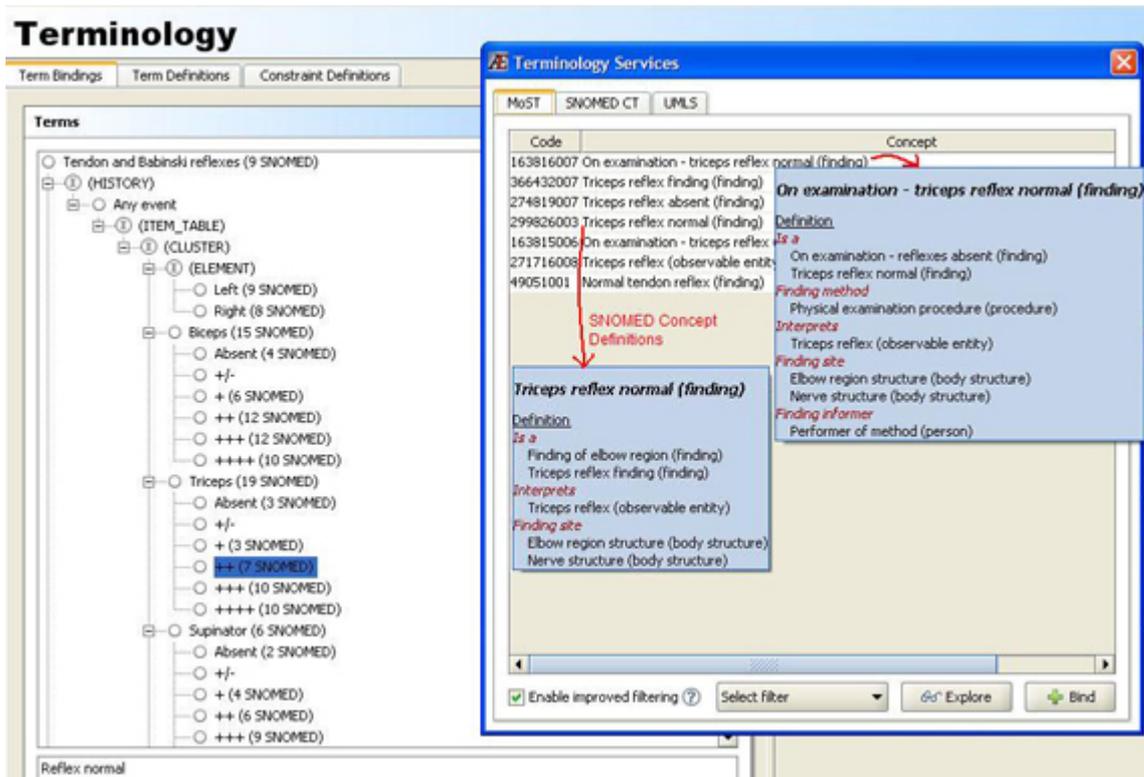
Normal reflex codes in SNOMED CT for conceptualising triceps reflexes. Displays *subsumption* relationship between the two concepts.
